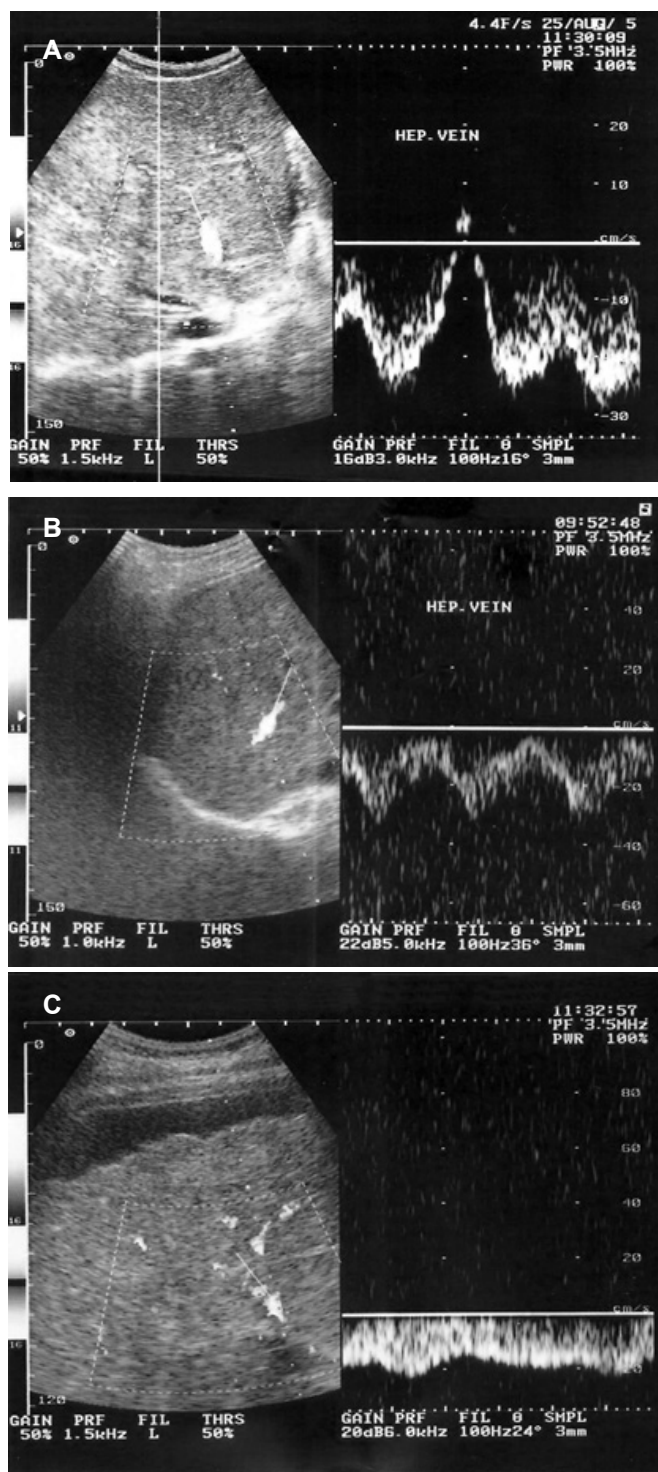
Doppler spectral waveforms of hepatic vein showing different flow patterns including;
